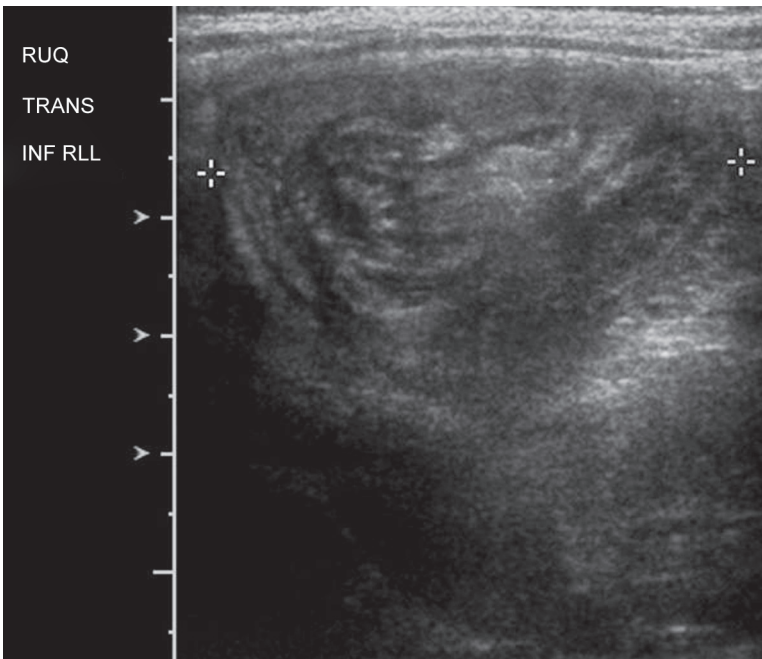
Ultrasound image of Intussusception
